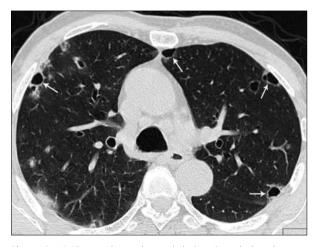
HRCT scan shows the cystic lesions in subpleural spaces [white arrows]
